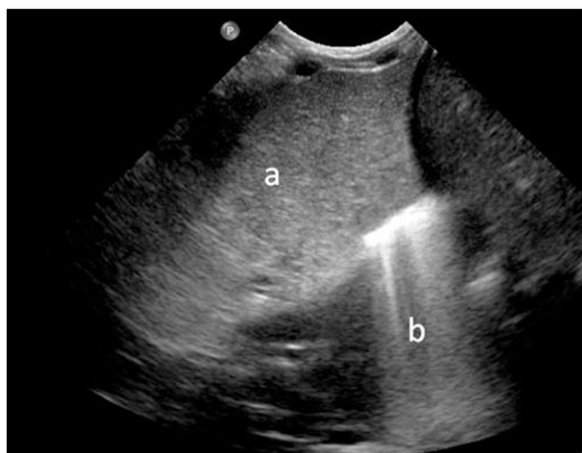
Ultrasound scan of the chest, right thorax with A) a large mass on the right, consistent with a consolidated lung with an intact diaphragm, and B) liver.
